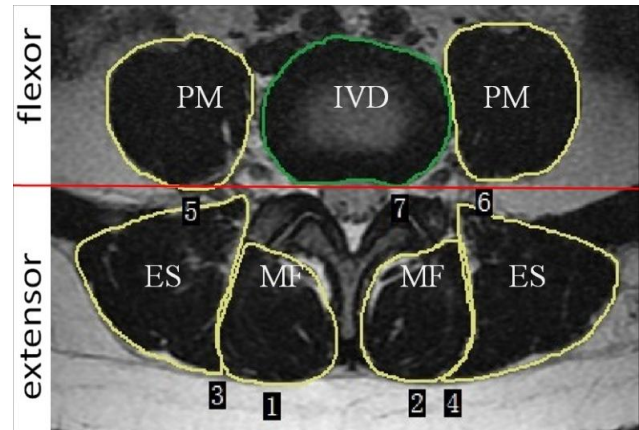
Axial T2-weighted MR image demonstrating measurement of the MRI signal intensity and the CSA of different LPSM and IVD by creating ROIs. Note: CSA, cross-sectional area; LPSM, lumbar paraspinal muscle; PM, psoas muscle; ES, erector spinae; MF, multifidus; IVD, intervertebral disc; ROI, the region of interest.
